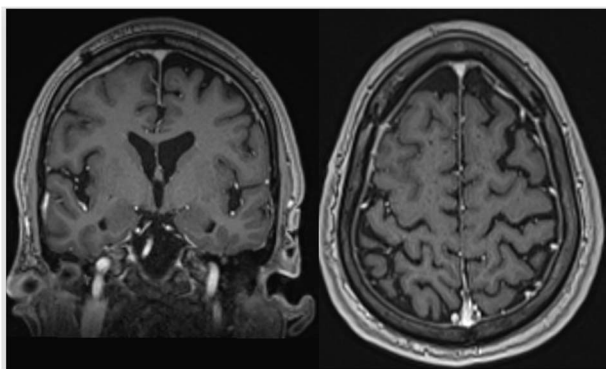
MRI brain after 8 weeks demonstrates marked improvement/resolution of pachymeningeal and leptomeningeal enhancement.
